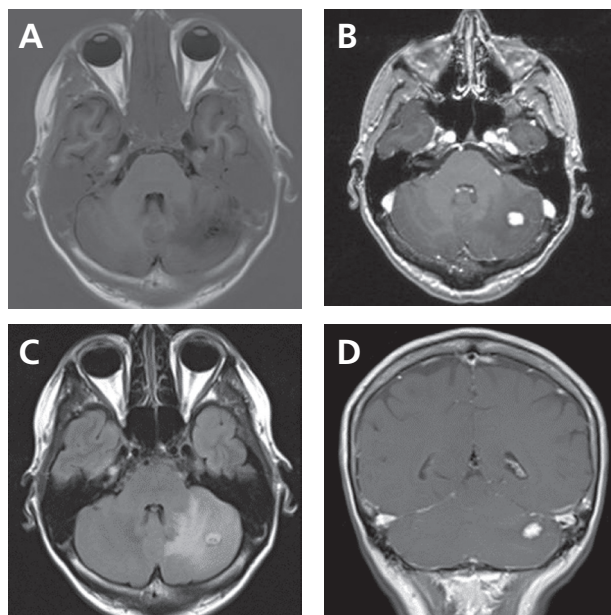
Preoperative MRI. (A) Axial T1-weighted image shows a hypointense lesion involving the left cerebellar hemisphere. (B) After gadolinium infusion, strong enhancement is seen sharply demarcated by the tumor's borders. (C) Axial fluid-attenuated inversion recovery (FLAIR) imaging shows a significant amount of vasogenic edema limited to the left hemisphere. (D) Coronal T1-weighted image after gadolinium infusion demonstrates cranial-caudal extent of the lesion.
